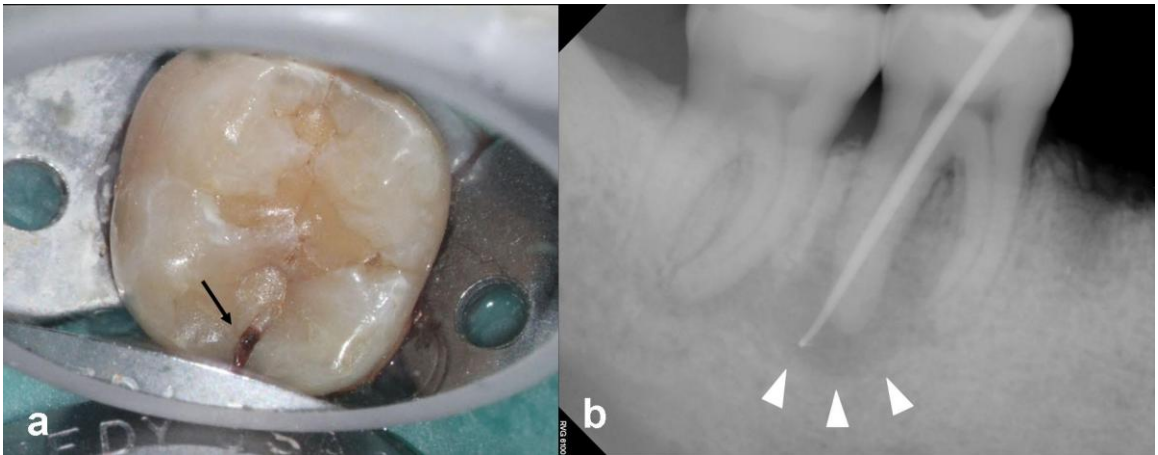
a) A 55-year-old male with mesial to distal occlusal fracture of tooth #31. B) The radiograph of the sinus tract traced and radiolucency around distal root of #31.
